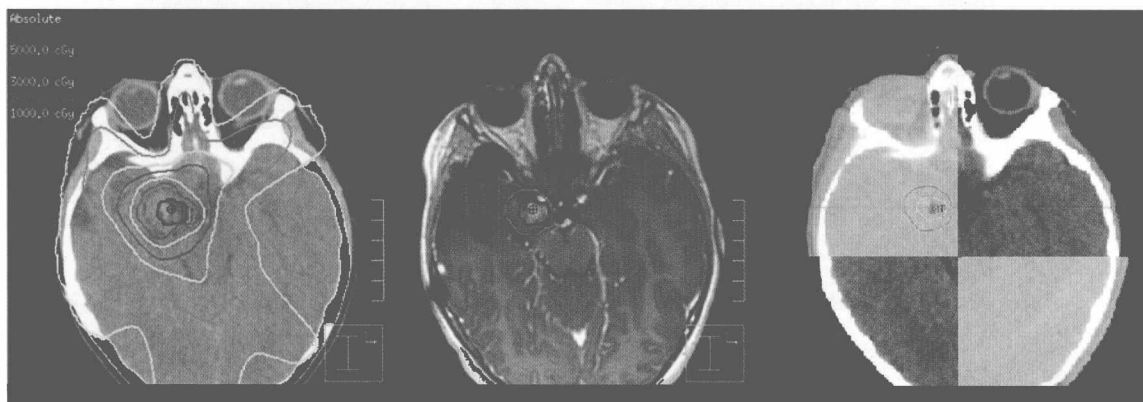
Radiation plan for a 12-year-old boy with recurrent ganglioglioma, prescription dose was 5400 cGy in 30 fractions (left panel). Fusion of the diagnostic MRI (middle panel) allows the delineation of the gross tumour volume (GTV, blue line) and planning target volume (PTV, green line) that incorporates a safety margin for tumour infiltration and daily setup variation. CT acquisition on the linear accelerator (right panel) allows co-registration and comparison of the 'CT of the day' (light grey checker) with the planning CT (dark grey checker) to detect and correct positioning variation with millimetre accuracy.
